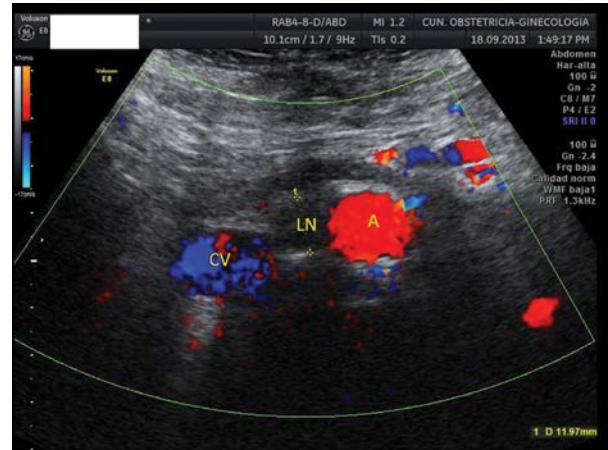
Transabdominal ultrasound showing a suspicious lymph node (LN) in para-aortic area. The lymph node is located between the aorta (A) and the inferior vena cava (ICV).
